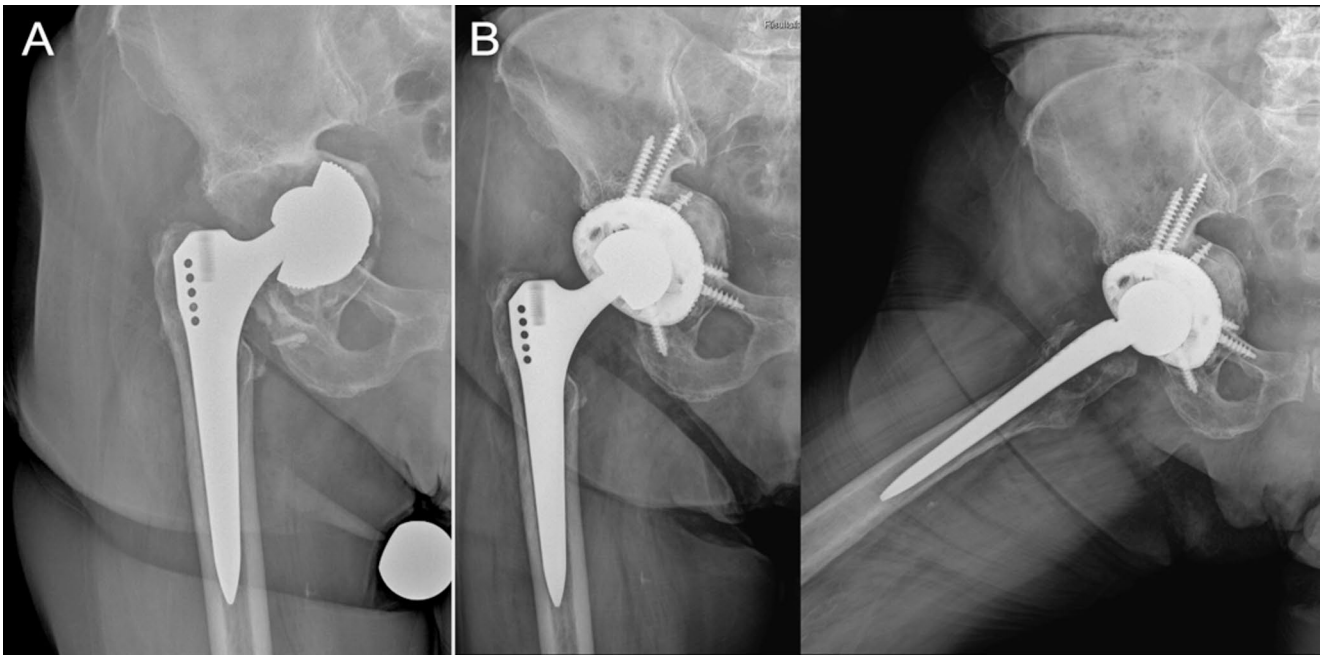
Clinical Case. 81 year-old woman, primarily treated with total hip arthroplasty for hip arthritis. A. Preoperative antero-posterior radiographs: aseptic mobilization with severe medial bone loss and substantial intra-pelvic migration of the acetabular cup, Paprosky III-B
